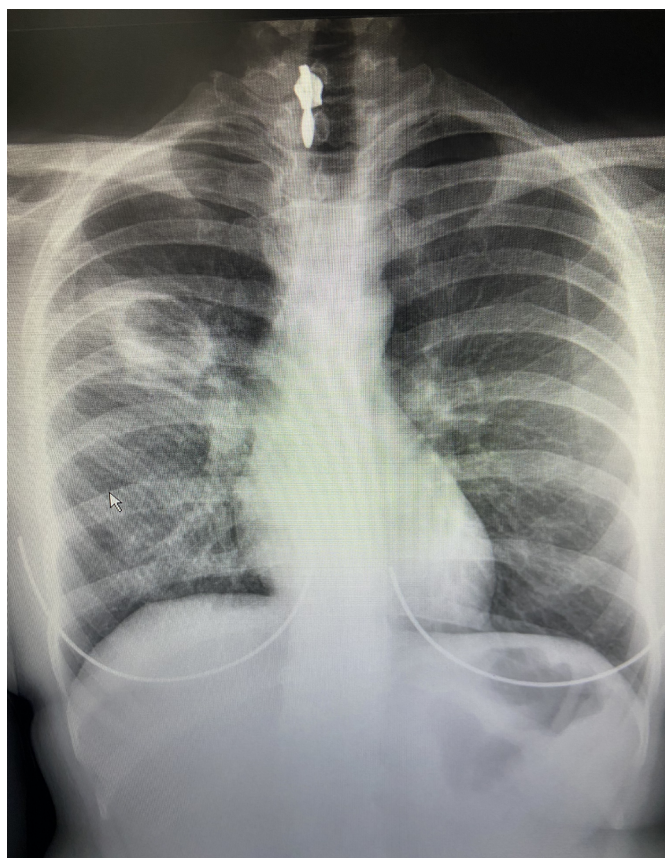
A cavitory lesion with an irregular inner wall in the right upper zone as shown in posteroanterior (PA) chest radiography
